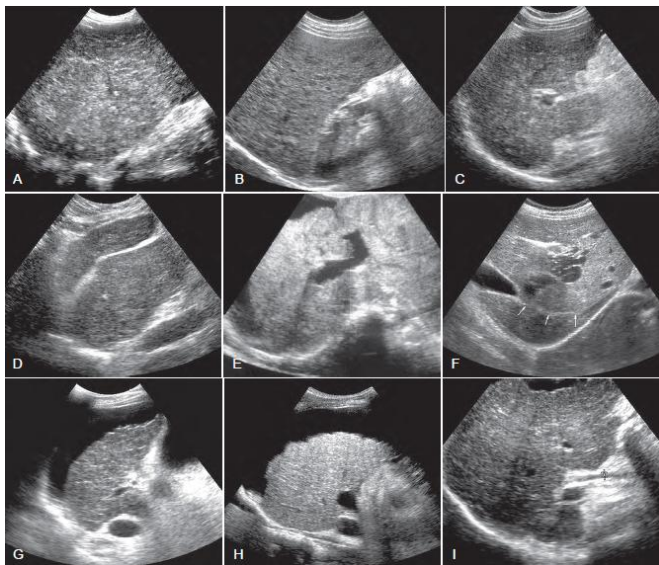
Cirrhosis: spectrum of appearances. *Top row, Parenchymal changes.* A, Coarse parenchyma and innumerable tiny, hyperechoic nodules. B, Coarse parenchyma and innumerable tiny, hypoechoic nodules. C, Coarse parenchyma and surface nodularity. *Middle row, Lobar redistribution.* D, Sagittal image showing an enormous caudate lobe. E, Transverse sonogram shows the right lobe is small, with enlargement of the left lateral segment. F, Subcostal oblique view showing a tiny right lobe of the liver, which is separated from the large left lobe by the main lobar fissure (arrows). *Bottom row, Contour abnormality.* G and H, Small, end-stage livers with surface nodularity, best appreciated in patients with ascites, as shown here. I, Liver contour varies greatly, as shown here, where a large nodule protrudes from the deep liver border.
